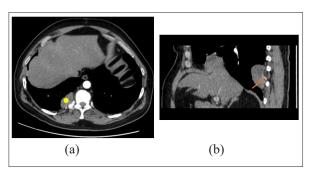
(a) Axial contrast-enhanced CT image showing a hypervascularized tumor (highlighted with a yellow star) located adjacent to the T9–T12 vertebral bodies. The mass extends medially into the paravertebral soft tissues. (b) Sagittal contrast-enhanced CT image demonstrating vascularization of the tumor from surrounding intercostal vessels (marked by the red arrow).
